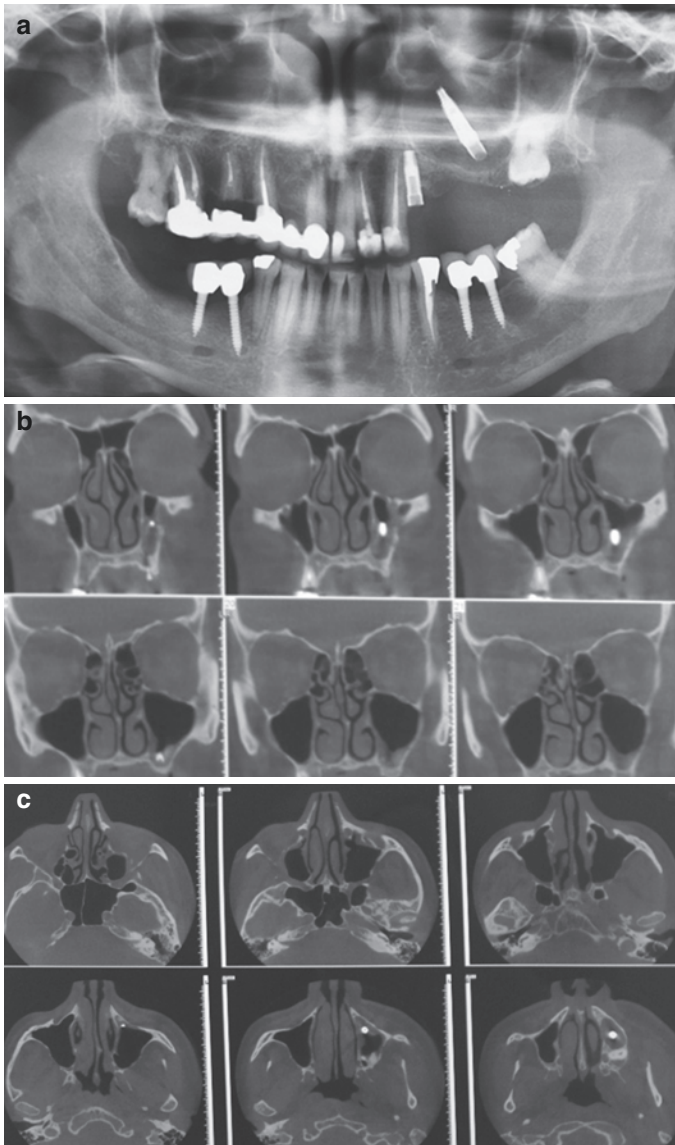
OPG (a), Coronal and axial CT scans (b, c) showing the position of the displaced implant inside the maxillary sinus. Note that the opacity around the implant, suggestive of an infectious reaction. The implant is located below the level of the maxillary arches, so it is resting on the sinus floor near the maxillary molar area. Lateral bone window is drilled out adjacent to the location of the implant determined by the CT scan (d). The Schneiderian membrane is incised. This is preferred to drilling into the Schneiderian membrane as incising the membrane will keep sound remnants of the membrane around the incision which are amenable to repair (e). Implant exposed after extending the window and incising through the membrane (f). The displaced implant removed (g). Schneiderian membrane sutured to the lateral sinus wall with 4-0 vicryl sutures (h). A bioresorbable collagen membrane is placed below the membrane covering the repaired segment (i). Alloplastic bone material is placed in the sinus below the membrane (j). Dental implants are placed in the same session (k). Post-op OPG (l)
